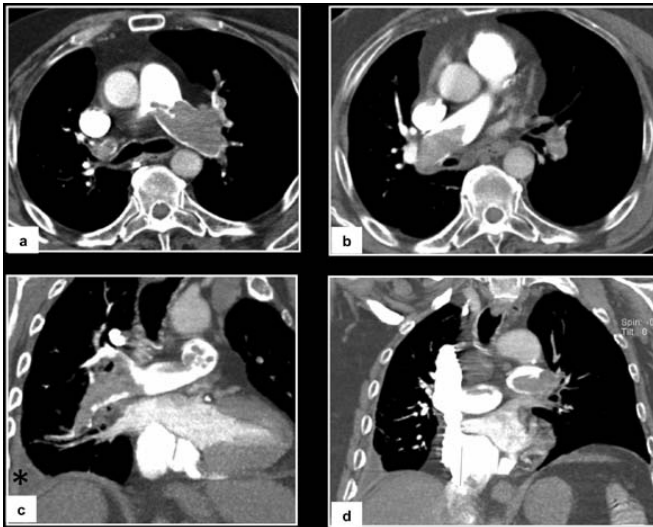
MDCT signs of acute PE. Complete obstruction. This catastrophic event ended with the patient's death, 2 hours after the performance of the CT exam. Note the huge thrombus in both pulmonary arteries, leading to enlargement of the vessels. Images a and b are axial slices, c and d are coronal reformations. Note the small pleural effusion on the right. The inferior vena cava reflux means probable right cardiac chambers overload.
